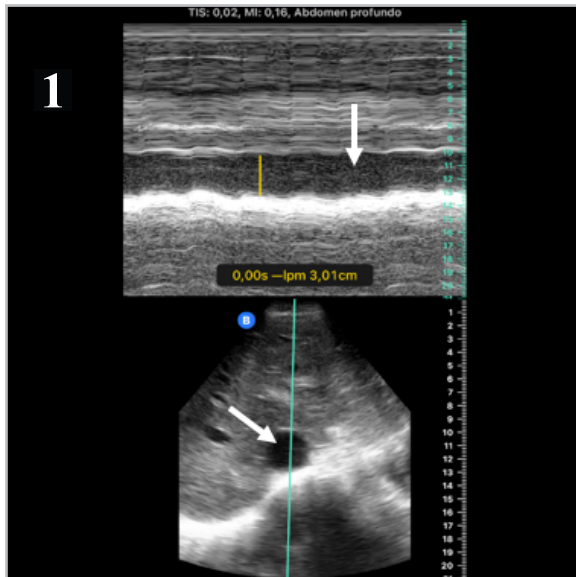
Abdominal ultrasound showing a dilated inferior vena cava with no respiratory variation.
